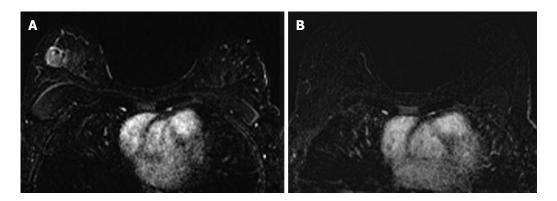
Forty-two years old woman with triple negative right breast cancer. A: Baseline axial T1-weighted post-gadolinium fat-saturated magnetic resonance image demonstrates a 3.6 cm unifocal mass in the upper outer quadrant; B: Post-neoadjuvant chemotherapy magnetic resonance imaging demonstrates complete resolution of the mass seen previously. Surgical pathology demonstrates biopsy site changes and expected changes related to chemotherapy with no evidence of residual cancer.
